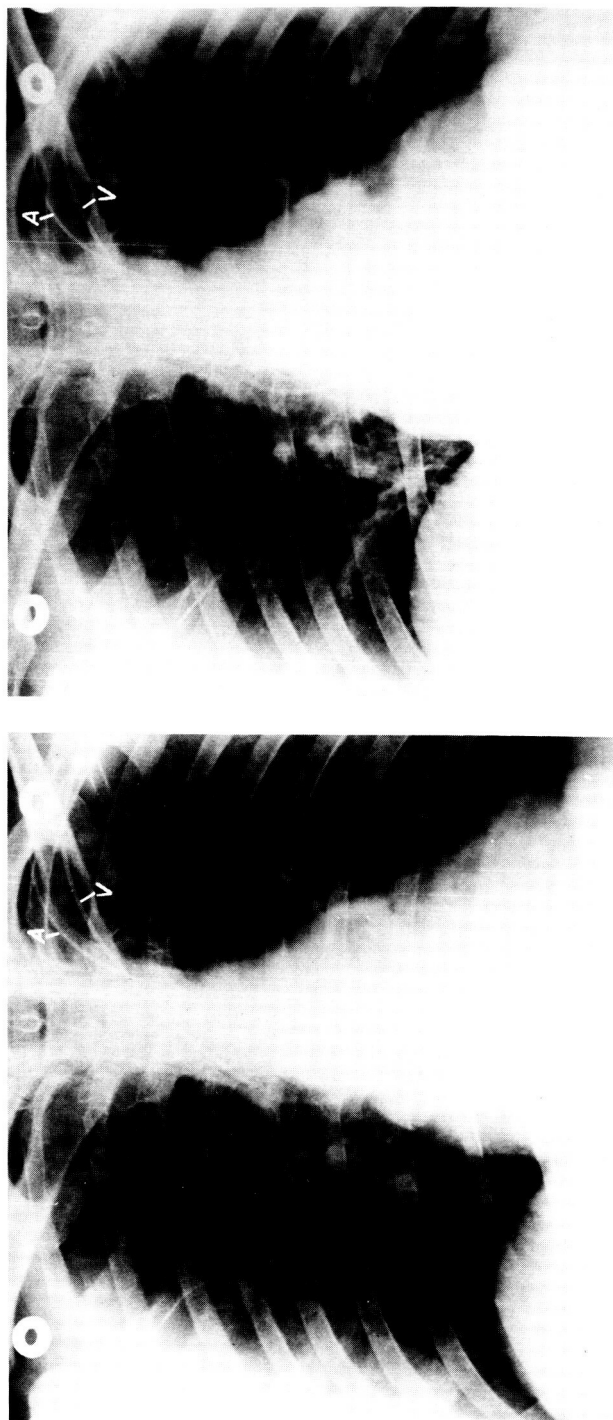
(a, *left*) Normal thoracic roentgenogram of a healthy 38-year-old man just before acceleration. (b, *right*) Same subject five minutes after termination of acceleration to 5.5 G for 2½ minutes while breathing 99.6 per cent oxygen. Note the focal areas of increased density indicative of atelectasis bilaterally, with associated diaphragmatic elevation. "A" denotes aortic catheter, "V" denotes venous catheter in right atrium.
